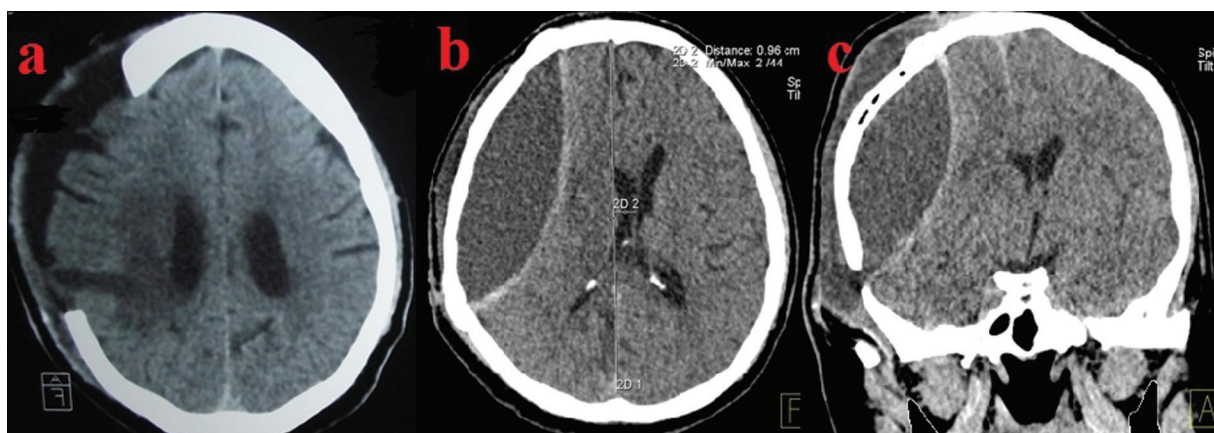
Pre-CP CT scan images (A) showing a “full” flap that necessitated LP to make space and seat the bone flap; postoperative CT scans (B, C) showing sub-flap epidural fluid collection causing mass effect and midline shift.
